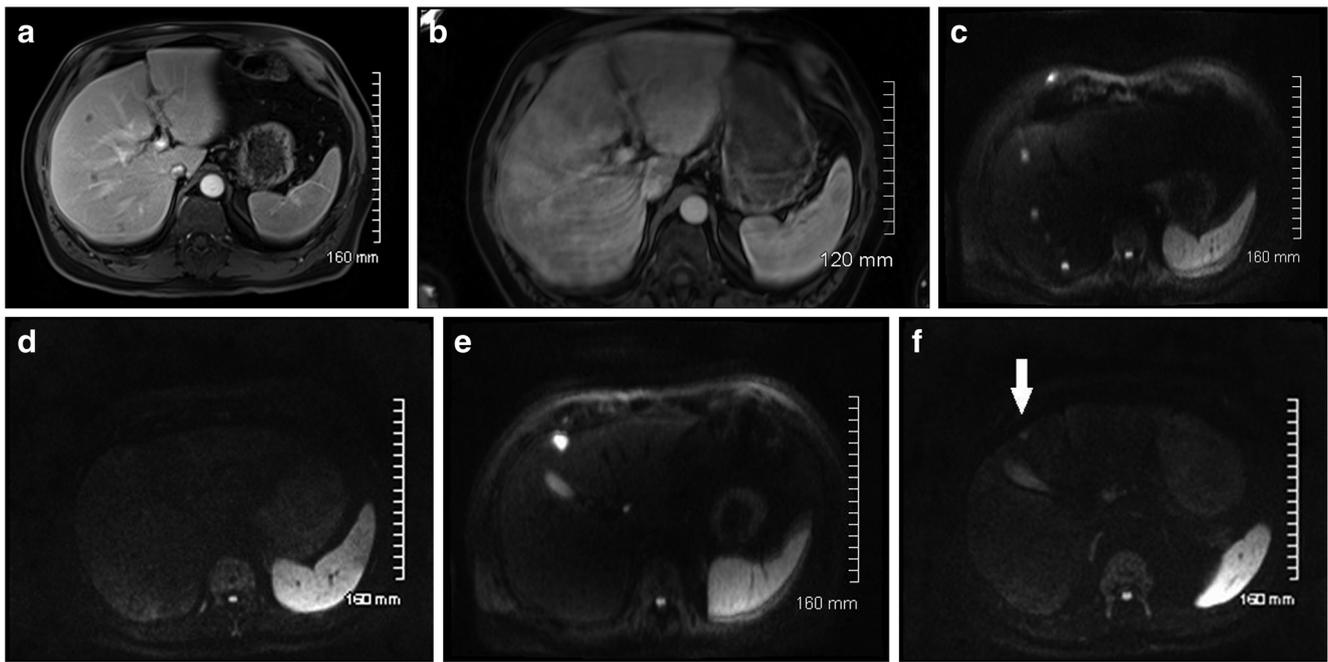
Sixty-two-year-old male with sigmoid colon adenocarcinoma. Arterial phase contrast-enhanced MRI of the liver (a) pre-treatment demonstrates multiple small liver metastases. B800 diffusion imaging of the liver pre-treatment (c, e) demonstrate restricted diffusion (high signal) within the liver metastases. Arterial phase contrast-enhanced MRI of the liver (b) 3 months post-SIRT demonstrates resolution of liver metastases. There is a geographical pattern of liver parenchymal enhancement
